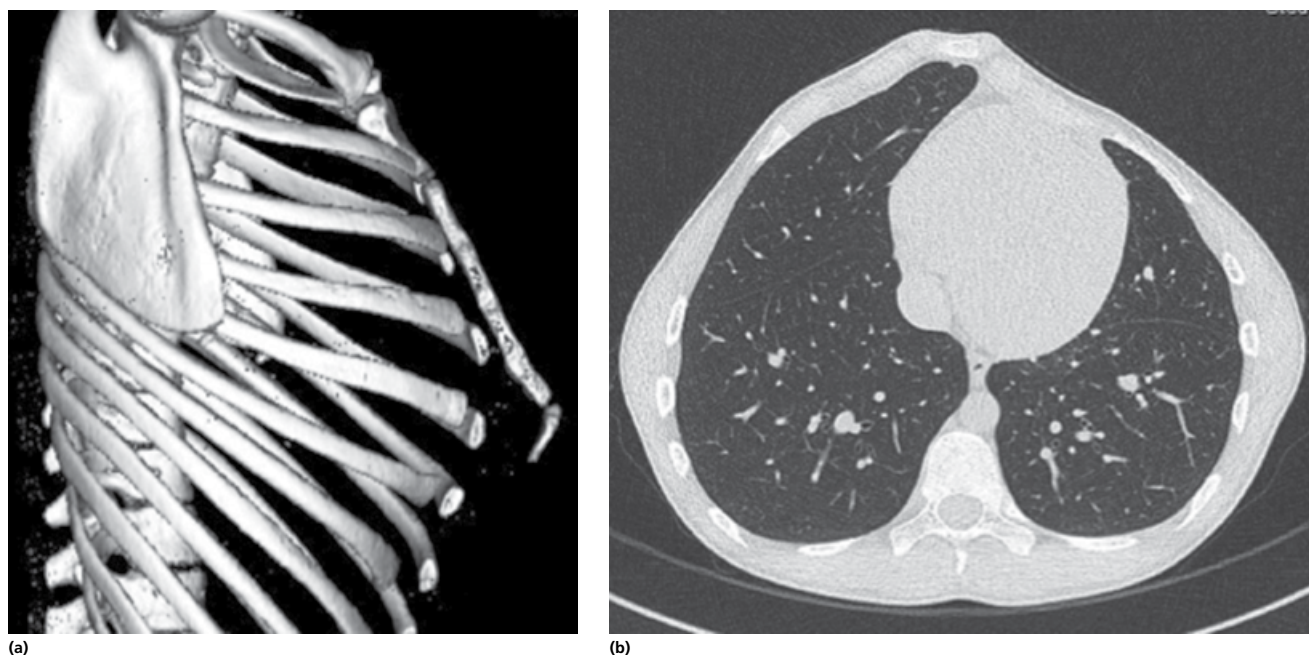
Pectus carinatum as seen on 3D CT reconstruction (a) and transverse CT scan (b). Note the 90° angulation between the body of the sternum and xiphisternum.
